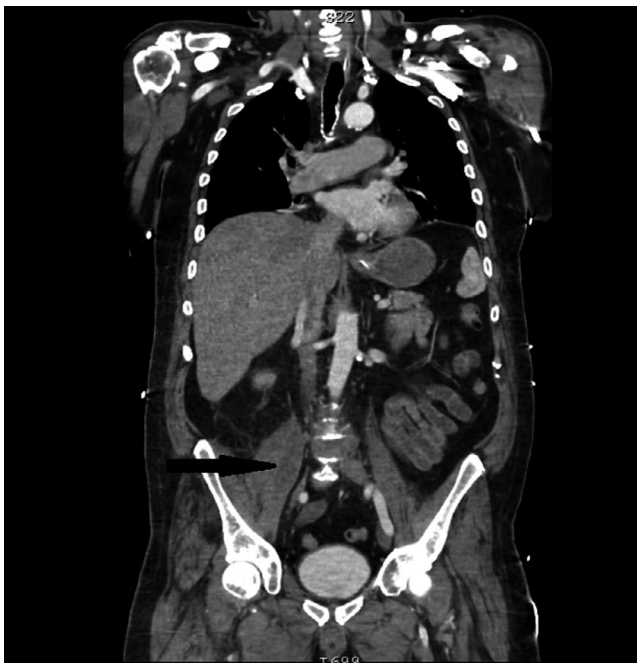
Contrast-computed tomography of the abdomen, pelvis, and thorax, with arrows pointing to right psoas muscles. Note the different sizes between right and left psoas muscle. The affected portion of the right psoas muscle is expand
